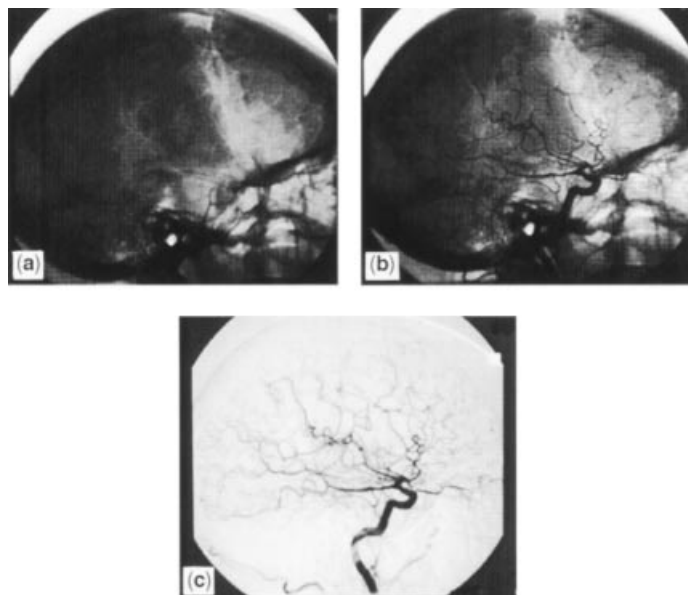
Subtraction angiography. Radiograph of a head before (a) and after (b) contrast agent injection. The difference image (c) shows only the arteries. Courtesy Dr. Barry Goldberg, Thomas Jefferson University.
